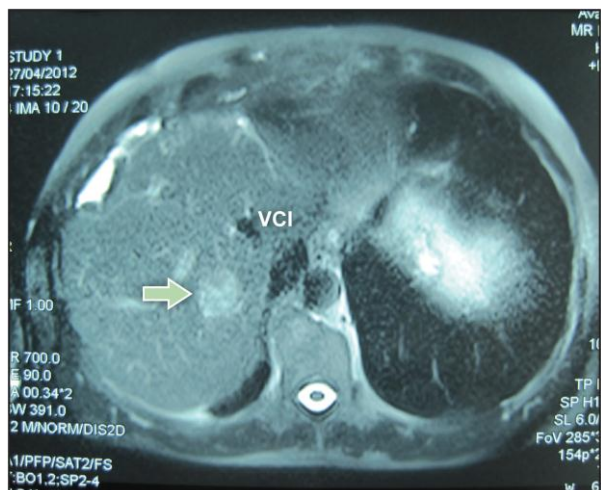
Pretreatment abdominal MRI demonstrating tumor in liver segment VIII.
